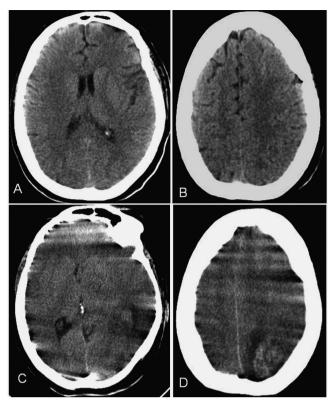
Computed tomography (CT) scan performed at the time of admission, at the level of the basal ganglia (A) and the convexity (B). Cranial CT scan performed at 9 days of admission, at the level of the basal ganglia (C) and the convexity (D). Despite the motion artefacts present in the study due to the patient's poor clinical condition, it is possible to observe a generalised decrease in sulci and ventricle size in relation to diffuse cerebral oedema.
